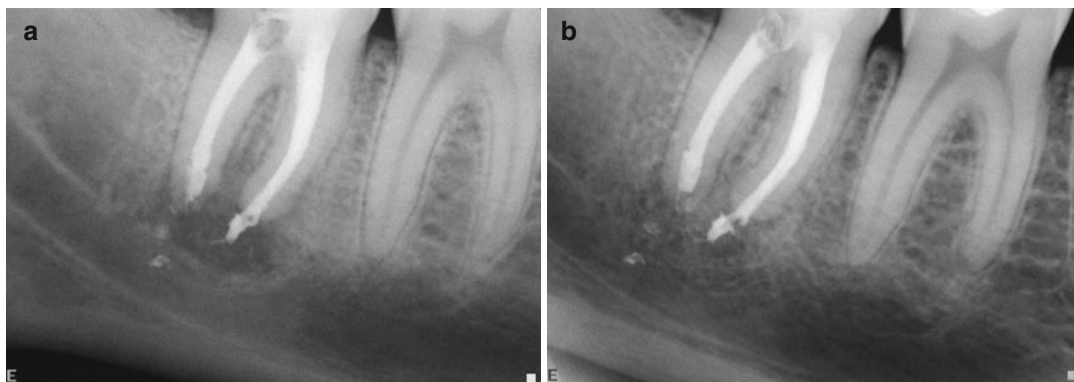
Nerve injury following an endodontic treatment of mandibular second molar. (a) Nonsurgical endodontic treatment in the mandibular second molar. Radiographic evidence of overfilling of the endodontic filling material in the vicinity of the IAN. The patient presented with IAN paresthesia following the treatment, and was treated by corticosteroids for 1 week and then was
